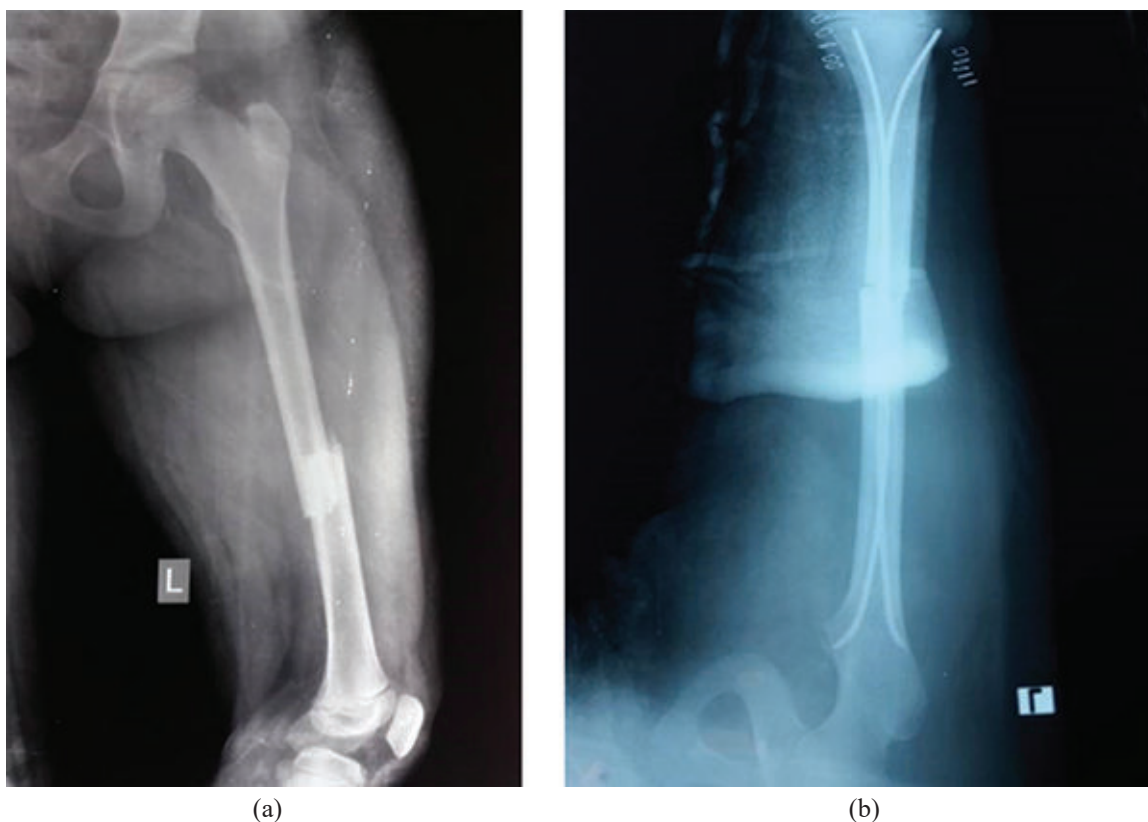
a) Pre-operative X-ray shows fracture shaft (left femur) of 12 yrs old children, (b) Post operative X-ray shows satisfactory fixation of fracture shaft (left femur) of the same children.
